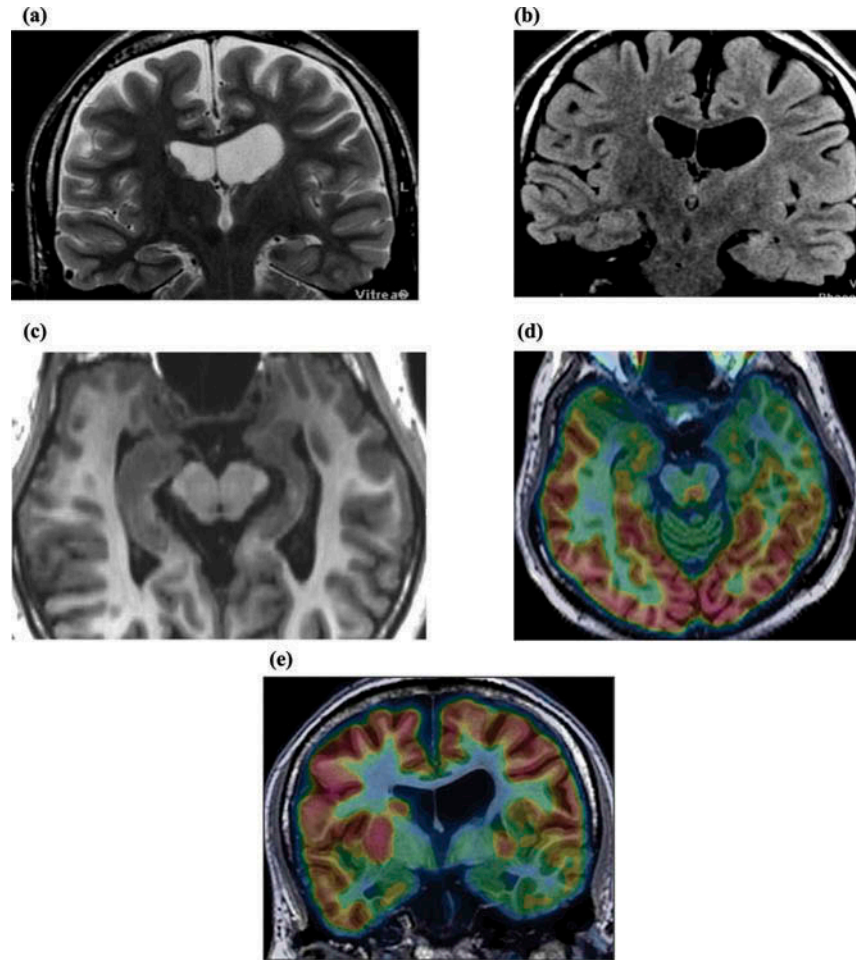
Poststroke brain imaging of Subject 2: (a) T2-weighted MRI showing a smaller left hippocampus and amygdala suggesting left mesial temporal sclerosis, (b) T2 FLAIR-weighted MRI showing increased signal within the smaller left hippocampus and amygdala suggestive of left MTS, (c) T1 MRI demonstrating the smaller left hippocampal structures, (d) axial PET indicated mild to moderate left anterior temporal hypometabolism and hypometabolism in the left basal ganglia and thalamus, (e) coronal PET showing left anterior temporal hypometabolism. The color scale on the PET images goes from green and blue to bright red and yellow. The colors are interpreted qualitatively to look for signal loss.
